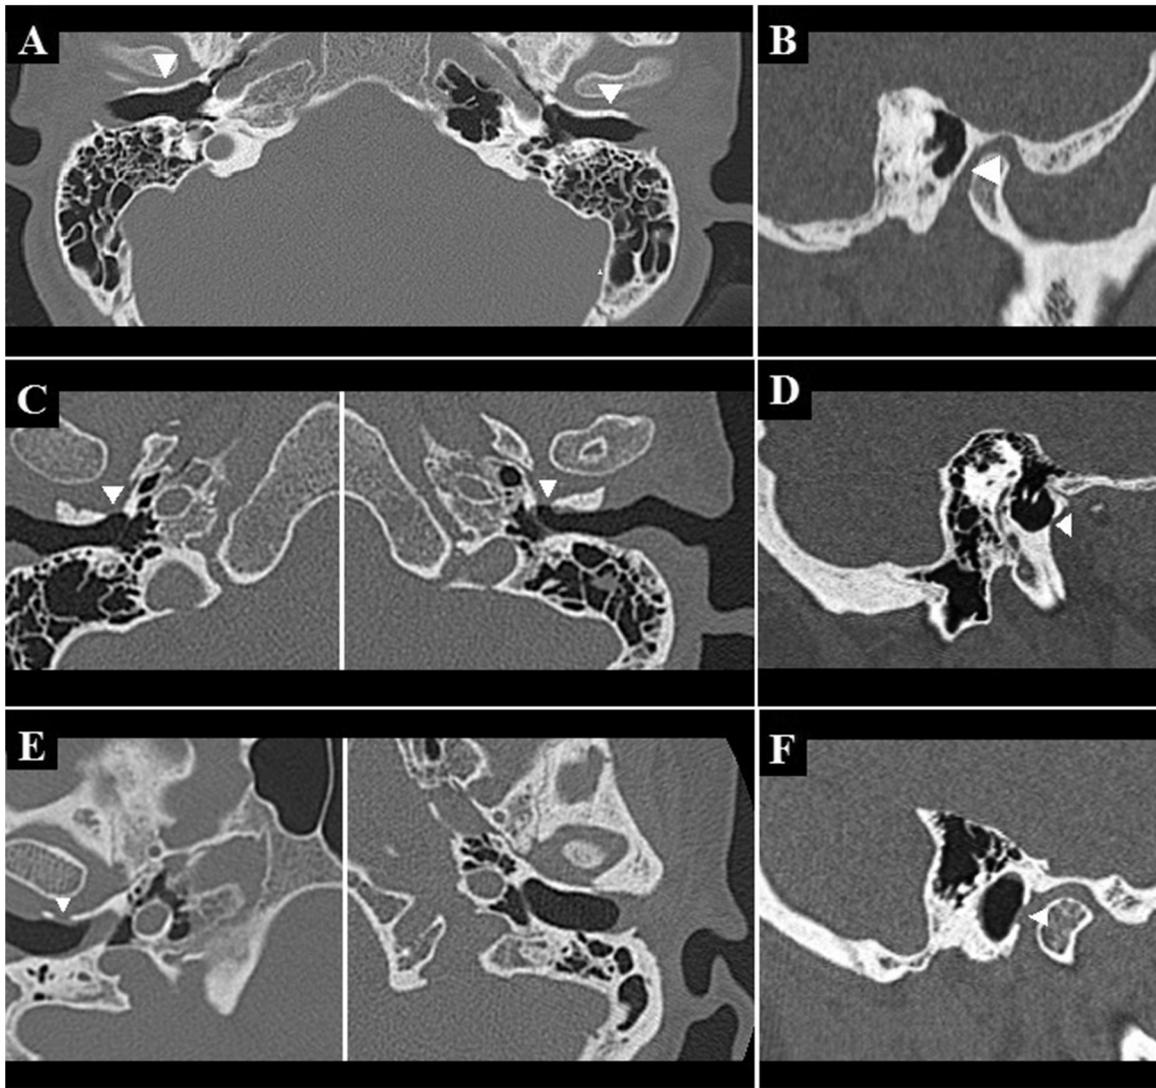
HRCT imaging of the temporal bone. A patient without FH: (A) axial plane; (B) sagittal plane. A patient with bilateral FH: (C) axial plane; (D) sagittal plane. A patient with unilateral FH (on the right side): (E) axial plane; (F) sagittal plane.
